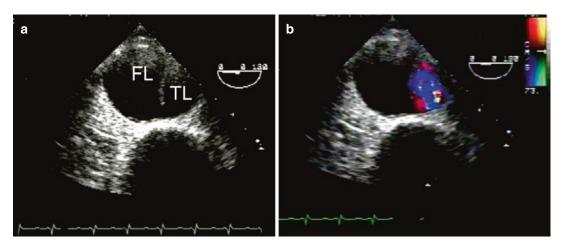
Transesophageal echo image of a descending aortic dissection in a patient with Marfan's syndrome. (a) Two-dimensional imaging demonstrates the true lumen
